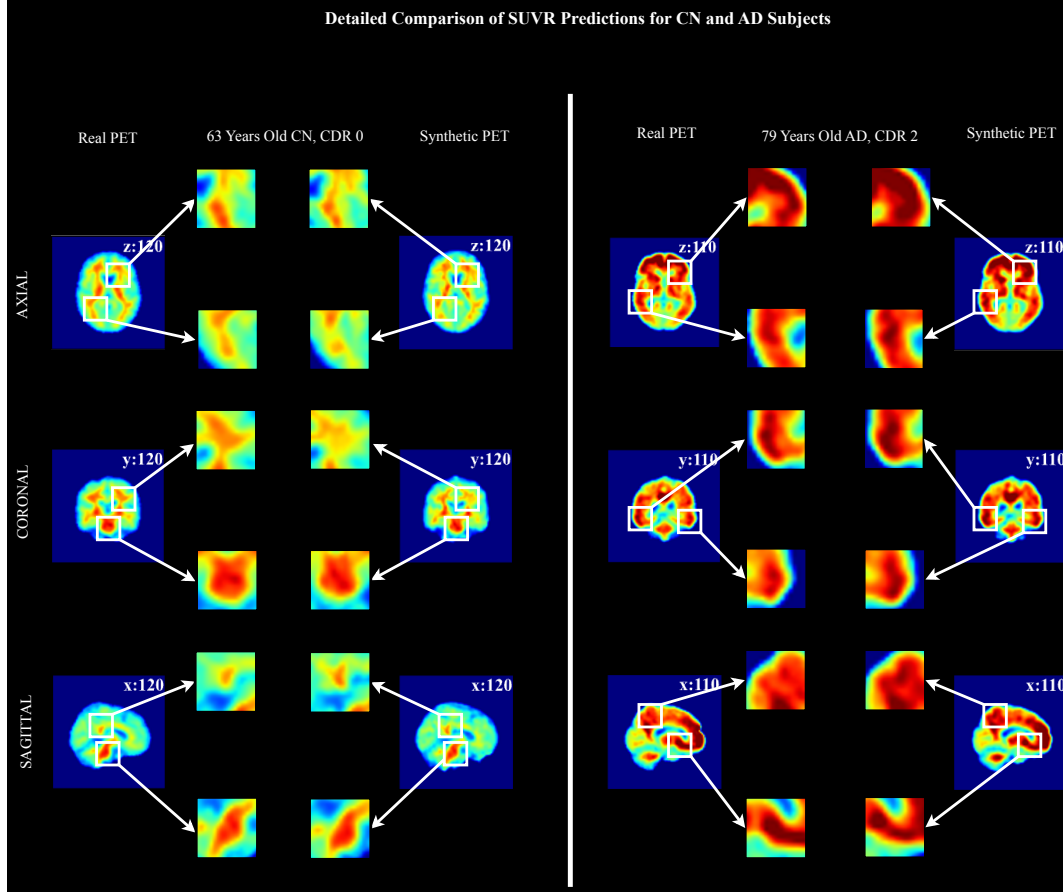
Detailed comparison in the standard uptake valuer Ratio (SUVR) prediction for cognitively normal (CN) and Alzheimer’s Disease (AD) subjects. It can be seen that there are minor discrepancies between the predictions of these two subjects, where the relevant ones were highlighted.
